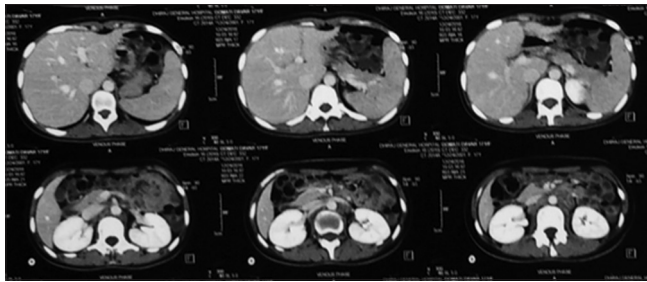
Contrast-enhanced computed tomography of the abdomen suggestive of pre- and para-aortic lymphadenopathy
